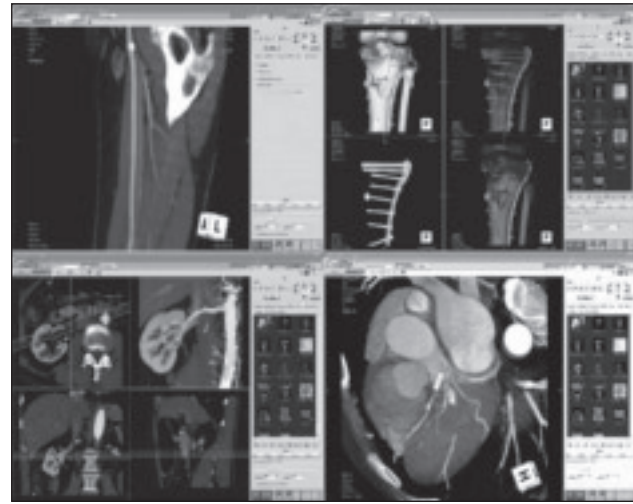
Sample screenshot images from thin-client software running on a regular PC without remarkable memory resources, processing power, or graphics capability. The technology allows real-time manipulation of volumetric images residing on the remote server. Three-dimensional, maximum intensity projection (MIP), and MPR images are calculated server-side, responsive to operator input on the client side, and streamed across the network for display on the client. Images shown: femoral artery (top left) in MIP mode, isolated from a run-off CT angiography acquisition with 1,500 slices; various volume-rendered views of a fractured tibial plateau (top right), postsurgery; MIP visualization of the renal artery (bottom left); and a volume rendered image of the coronary arteries (bottom right), revealing a stent and calcified plaque in the proximal left anterior descending artery. (AquariusNET Client software image courtesy of TeraRecon, Inc.)
